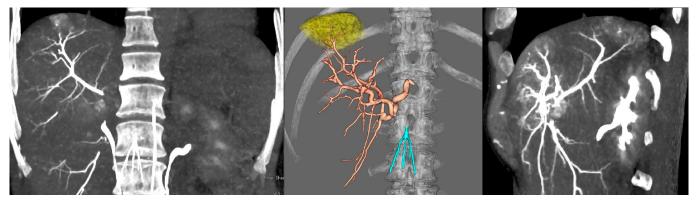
Helical CT of common hepatic showing Coronal, 3D VR and Sagittal views
